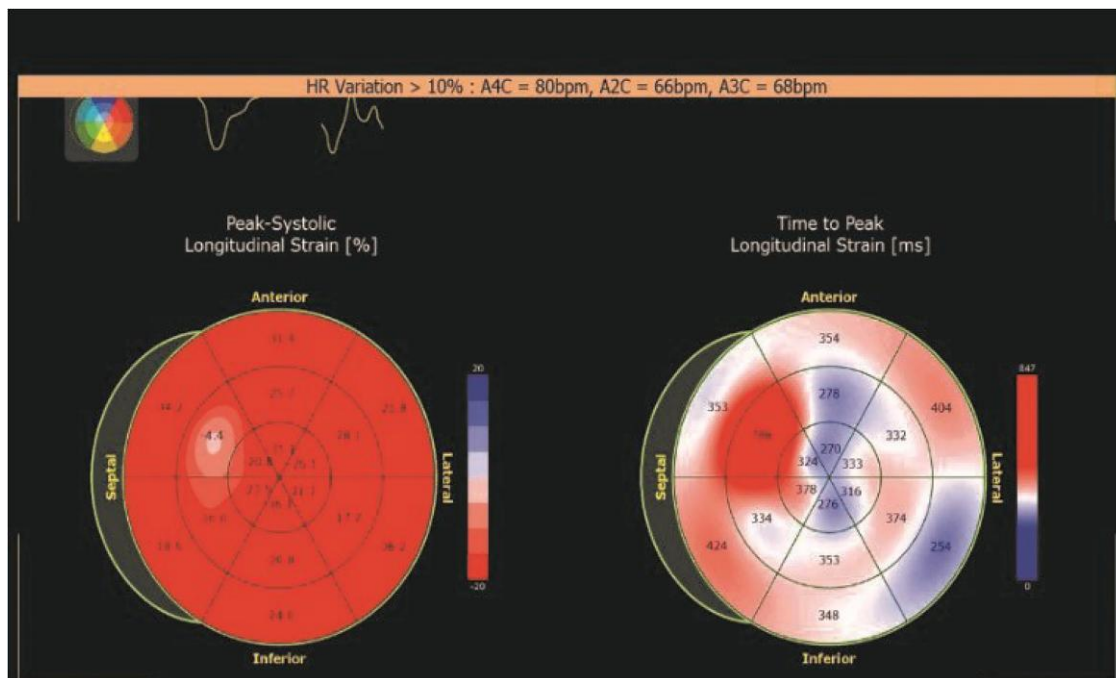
Strain imaging echocardiography: regional longitudinal strain shows mildly depressed left ventricular function at anteroseptal and infero-septal area.
